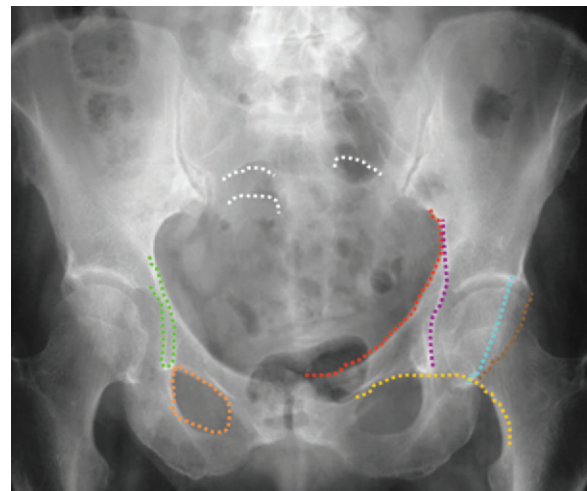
AP radiograph shows the key contour lines for evaluating the pelvis: iliopectineal (red), ilioischial (purple), anterior rim (blue), posterior rim (brown), Shenton (yellow), teardrop (green), obturator (orange), and sacral arcs (white). AP radiographs are helpful for assessing pelvic symmetry and anterior ring, iliac wing, and transverse process fractures.
